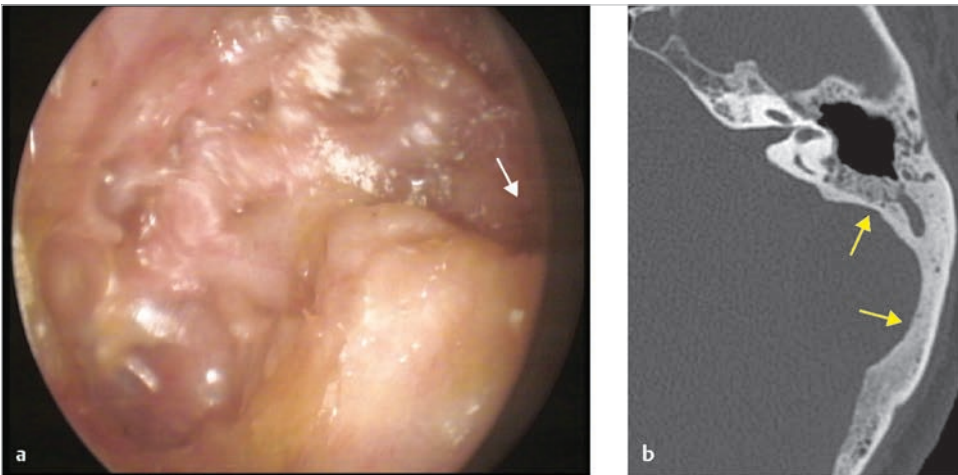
The patient underwent cholesteatoma surgery elsewhere followed by continuous otorrhea and visited our office with dull pain in retroauricular region. Otoscopic examination showed wet inflamed cavity especially in the area of mastoid tip (*white arrow*) with the high facial ridge (*a*). The axial CT (*b*) shows round-shaped bone erosion in the posterior face of the temporal bone (*yellow arrows*).
